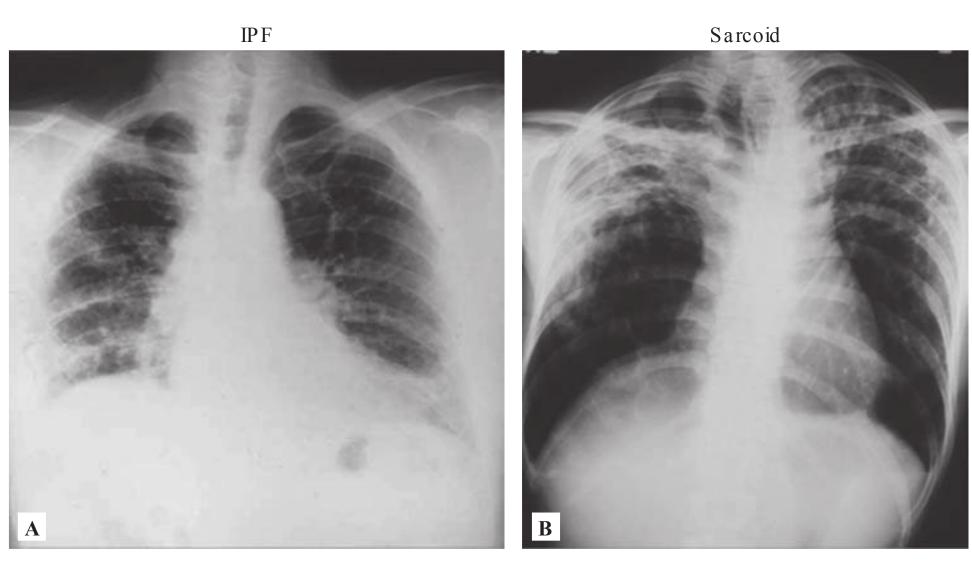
Representative chest x-rays that can be seen in patients with idiopathic pulmonary fibrosis (IPF) and sarcoid. IPF is characterized by basilar predominant interstitial markings. By contrast, sarcoid typically shows an upper lobe distribution of fibrosis which may also be accompanied by bilateral hilar adenopathy.
